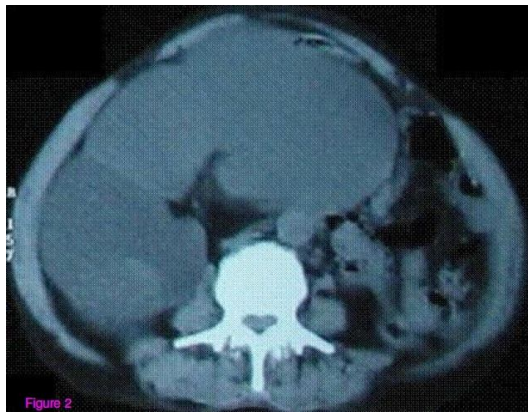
Abdominal CT Scan shows cystic renal mass crossing midline
